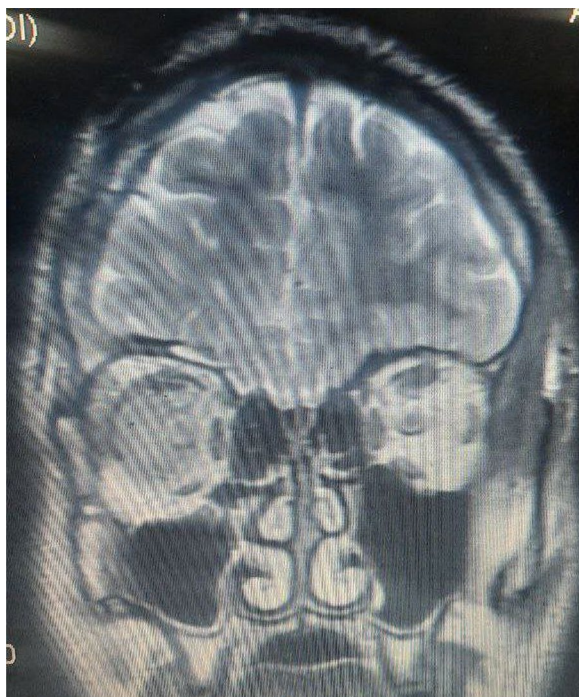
(Magnetic resonance imaging after surgery) magnetic resonance image in the coronal plane shows complete removal of the encephalocele, the expansion of the subarachnoid spaces in the right section disappears, and the brain returns to its normal size
